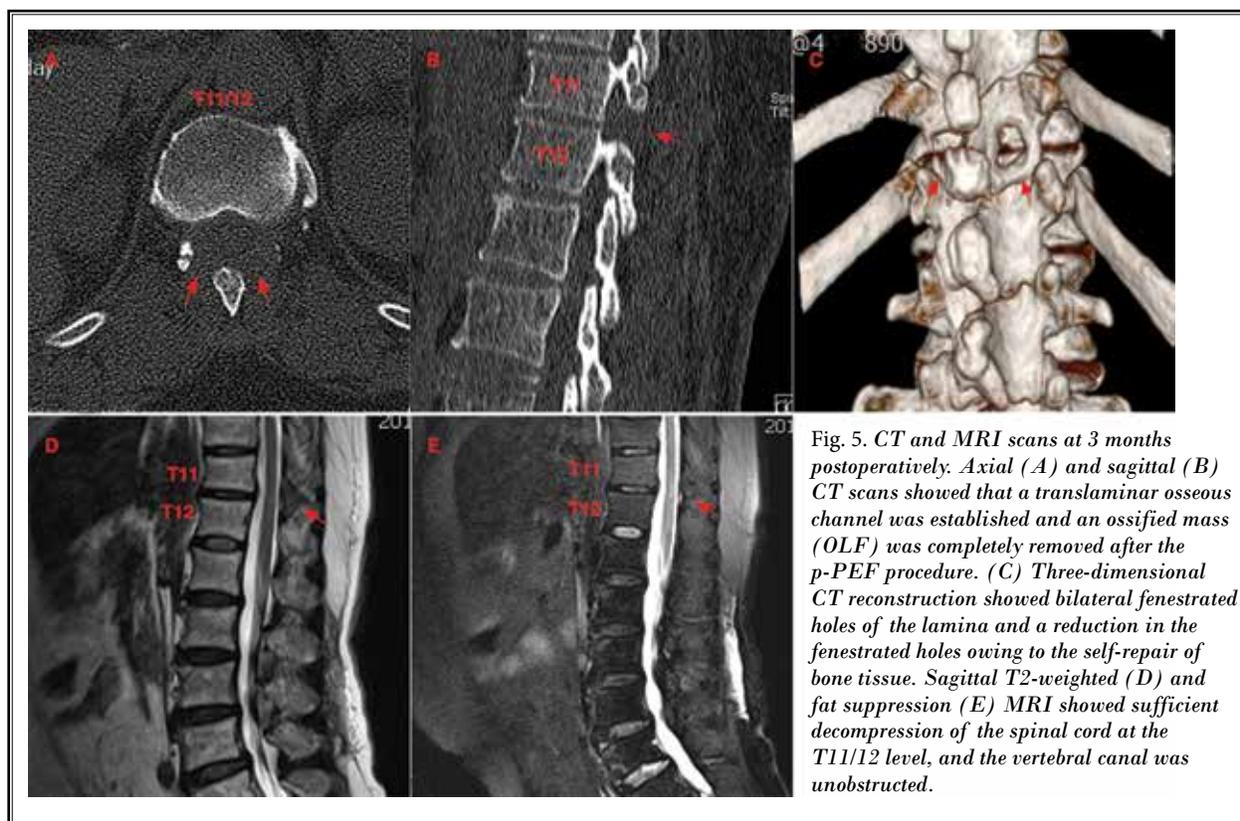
CT and MRI scans at 3 months postoperatively. Axial (A) and sagittal (B) CT scans showed that a translaminar osseous channel was established and an ossified mass (OLF) was completely removed after the p-PEF procedure. (C) Three-dimensional CT reconstruction showed bilateral fenestrated holes of the lamina and a reduction in the fenestrated holes owing to the self-repair of bone tissue. Sagittal T2-weighted (D) and fat suppression (E) MRI showed sufficient decompression of the spinal cord at the T11/12 level, and the vertebral canal was unobstructed.
